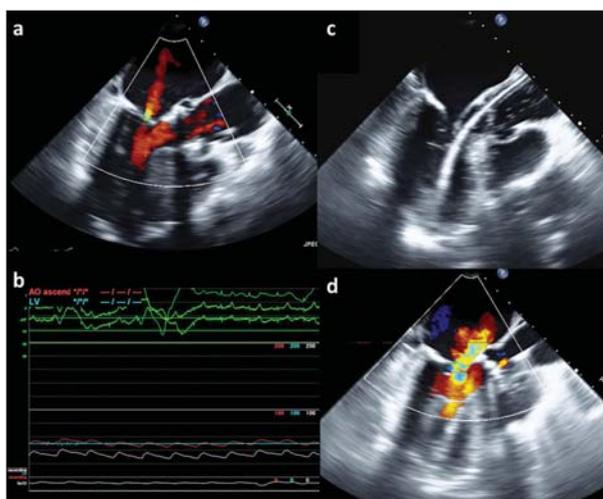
Severe hypotension and acute severe mitral regurgitation due to a distortion of the mitral apparatus by the stiff wire; transesophageal echocardiogram revealed (a) mild mitral regurgitation; (b) invasive pressure monitoring showed severe hypotension; (c) transesophageal echocardiogram: Lunderquist Stiff Wire is poorly positioned in the left ventricle and is causing tethering of the anterior mitral leaflet; (d) transesophageal echocardiogram: significant mitral regurgitation due to malpositioned stiff wire in the left ventricle.
